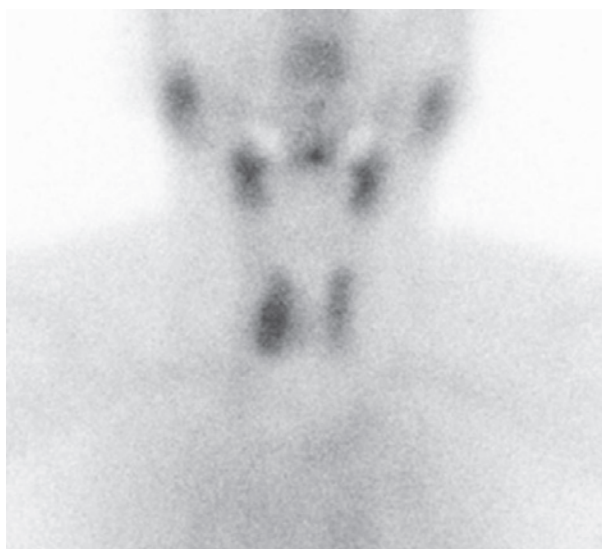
Thyroid gland technetium scintigraphy nine months after the treatment. The abnormal accumulation in the right lobe has decreased and accumulation in the left lobe is apparent.
